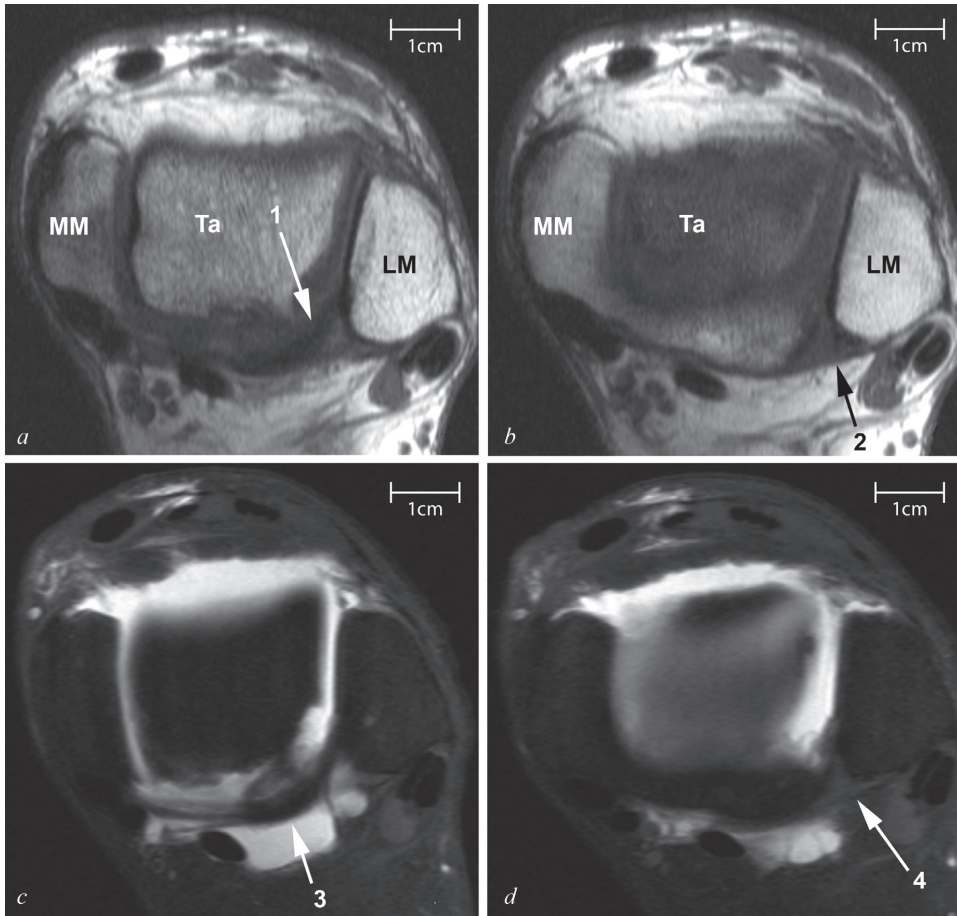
Axial proton-density-weighted MR images (*a, b*) and axial T1-weighted MR images with fat suppression with intra-articular contrast (*c, d*) at the level of the tibiotalar joint, in the same patient (female, 47 years). The transverse ligament (1) originates postero-medially from the fibula, just above the fibular fossa, and inserts on the dorsal ridge of the tibia. It forms a labrum-like structure to keep the talus from moving posteriorly (*a*). The posterior tibiofibular ligament (PTIFL) (2) is visible 5 mm above this level, which originates from the postero-medial corner of the fibular malleolus and inserts on the posterior tibial tubercle (*b*). The transverse ligament (3), extends like a thick band along the entire border of the posterior tibial ridge, where it serves as a labrum for the talus (*c*). The PTIFL (4) is short and triangular-shaped and bridges the fibula and tibia posteriorly (*d*). MM, medial malleolus; LM, lateral malleolus; Ta, talus.
